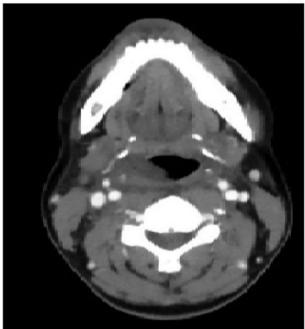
(a & b) Oedema narrowing the laryngeal airway from the right side at the supraglottic level, observed on axial computed tomography scans of the neck.
